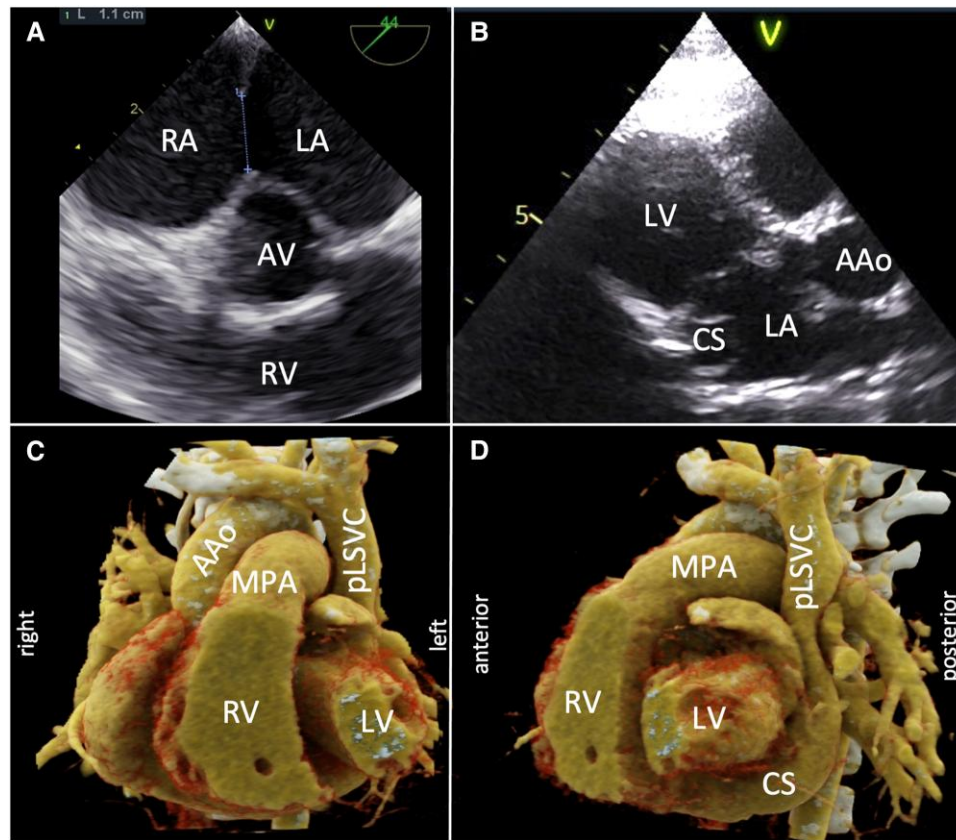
Transoesophageal echocardiography (modified mid-oesophageal aortic valve short-axis view, A)—atrial septal defect of 1.1 cm with almost no rim towards the aorta. Transthoracic echocardiography (modified long-axis view, B)—dilated coronary sinus can be seen in the left atrium. Computed tomography (coronary plane, C; sagittal plane, D)—persistent left superior vena cava with opening into a dilated coronary sinus and agenesis of the right superior vena cava. AAO, ascending aorta; AV, aortic valve; LA, left atrium; LV, left ventricle; MPA, main pulmonary artery; RA, right atrium; RV, right ventricle.
